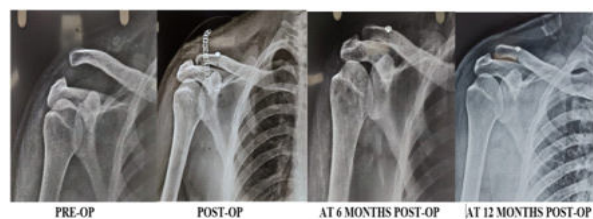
Pre-operative and Post-operative Roentgenographs.
